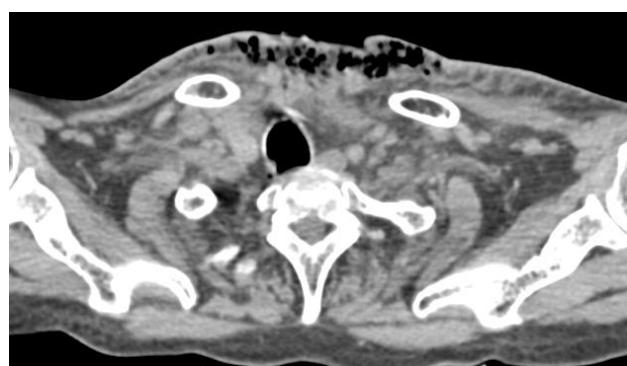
Computed tomography imaging of neck and thorax showing multiple air foci over anterior aspect of neck and chest.
